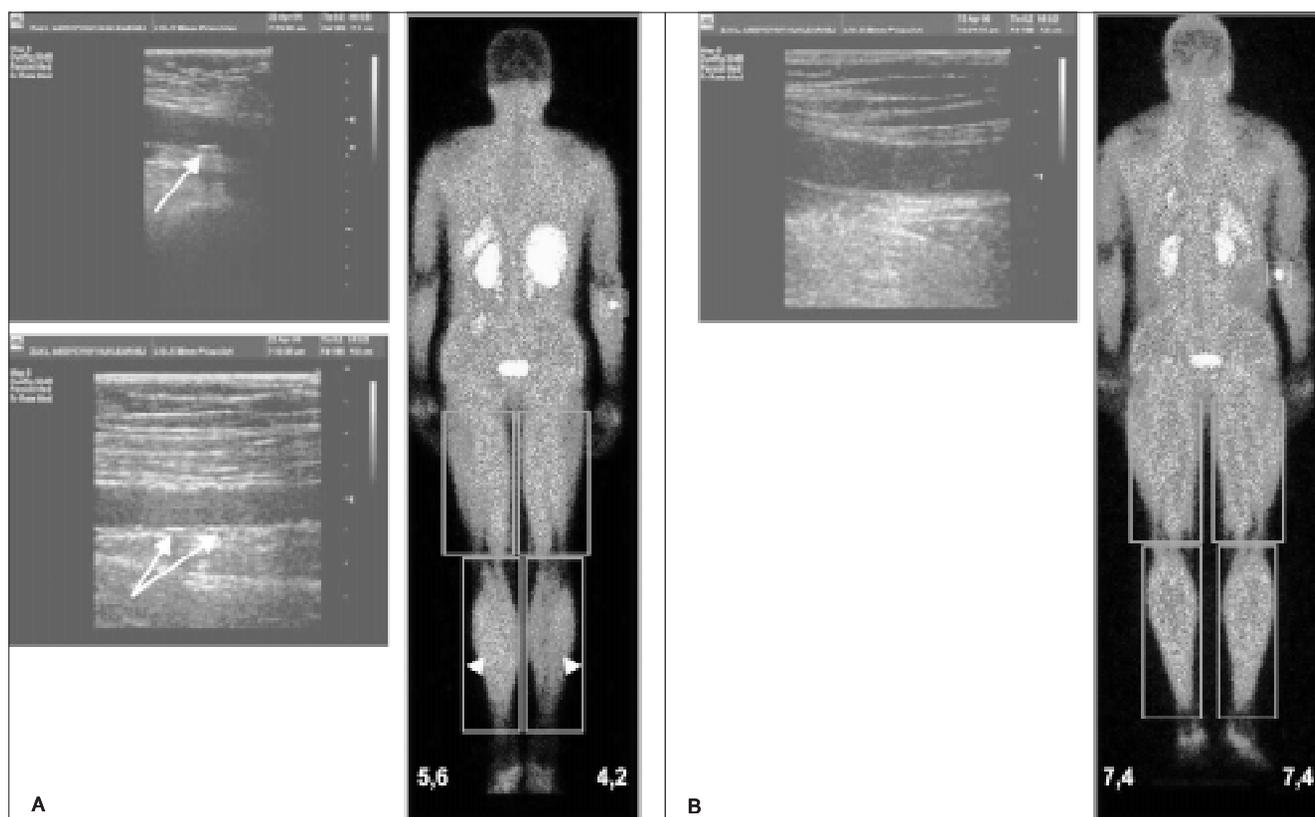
Whole body scintigrams with regions of interest and ultrasonographic images of a femoral superficial artery with (group I) atherosclerotic changes; B. Whole body scintigrams with regions of interest and ultrasonographic images of a femoral superficial artery without atherosclerotic changes; long arrows show calcifications and atherosclerotic plaque in intima-media of artery. Short arrows — asymmetry in Rph uptake in calf muscles. Values of stress perfusion indices are shown at the bottom of scintigrams.
